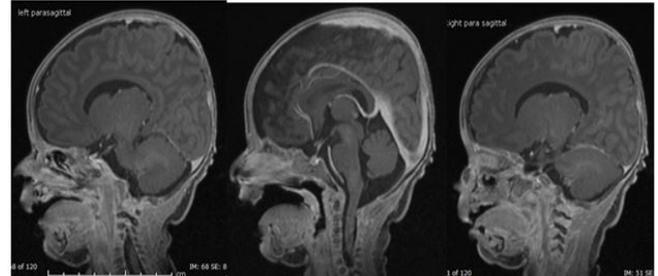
Magnetic resonance image of brain with intravenous contrast shows no filling defect or evidence of sinus thrombosis.
